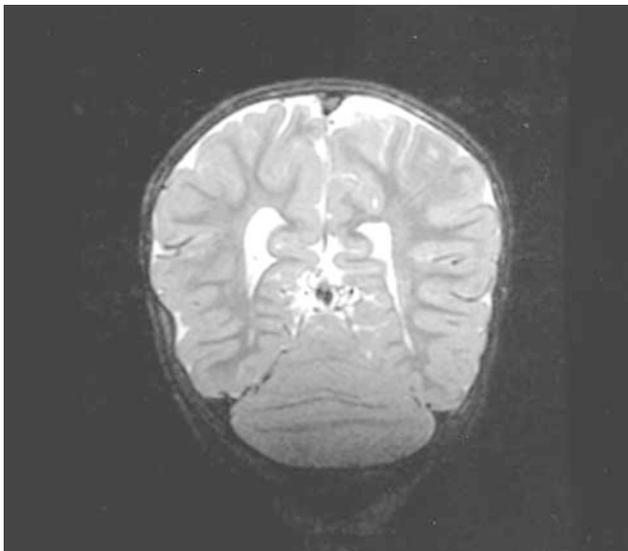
Coronal T2 weighted MRI, taken at 16-month-old, demonstrated the horizontal orientation and continuity of the cerebellar folia across the midline. After the insertion of ventriculo-peritoneal shunt (not shown), there was reduction in the ventriculomegaly.
